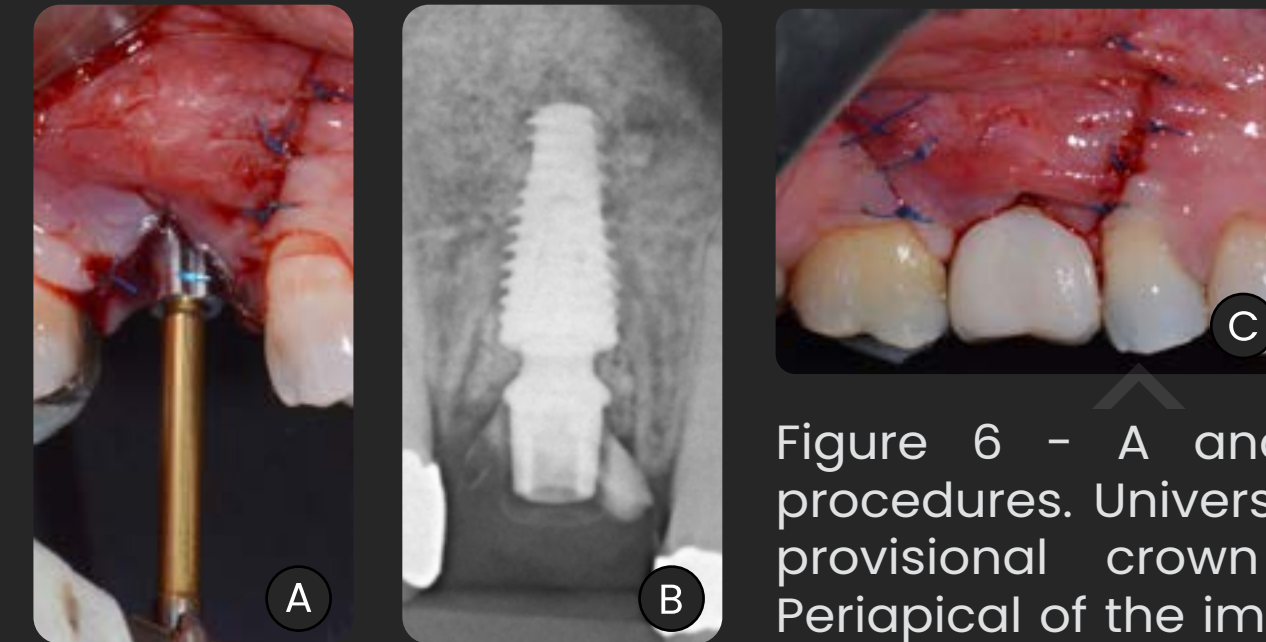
A and B: Prosthetic procedures. Universal abutment and provisional crown installation; C: Periapical of the immediately loaded implant.
